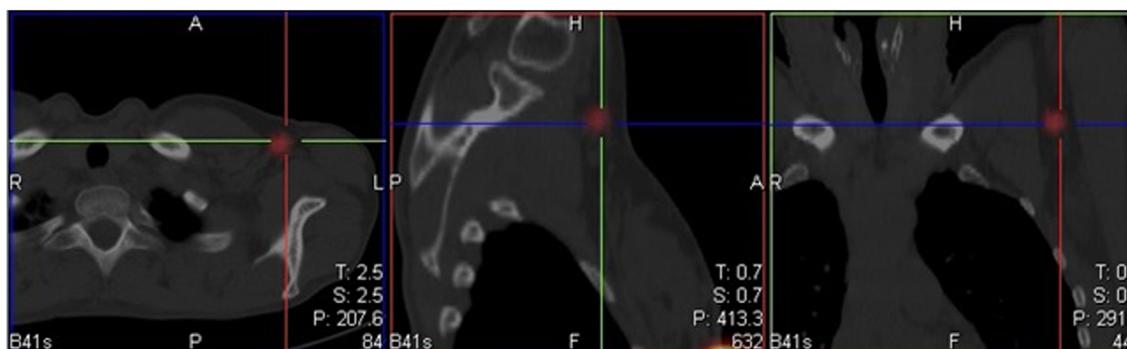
SPECT-CT images of the apical sentinel lymph nodes (axial, sagittal and coronal views).
